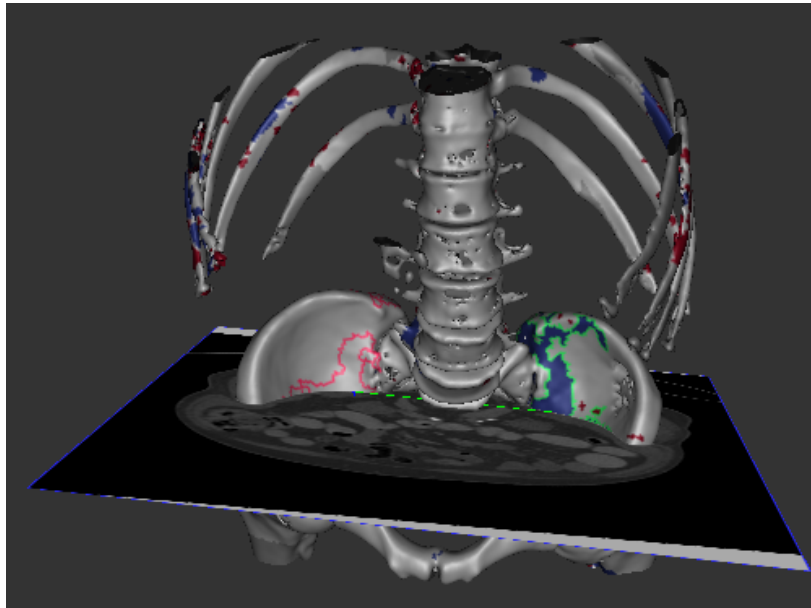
An example of re-slicing the CT data at a user selected location. A user can click on the mesh to calculate a re-sliced CT image at that location. Figure 2.29 shows this resliced CT image without the mesh. The CT data is from the Addenbrooke's Hospital CT Data Collection.
